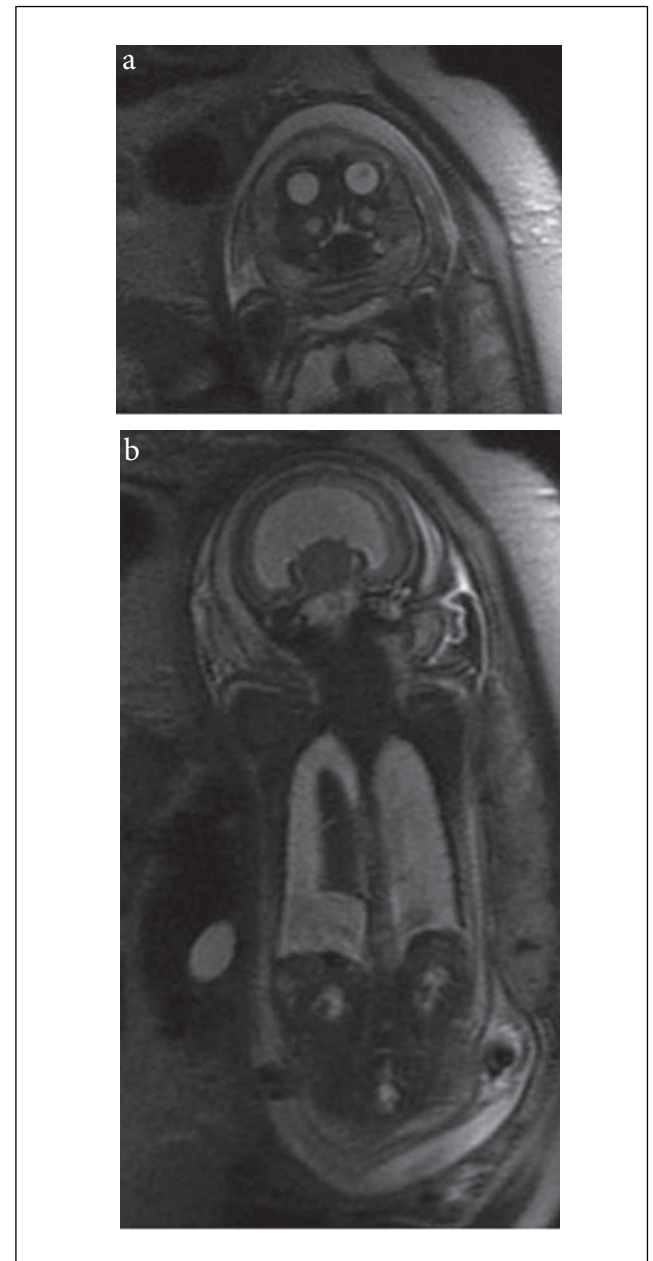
Fetus, 31 weeks GA, case no 14. MRI, SSFSE sequence, T2WI, coronal plane.
